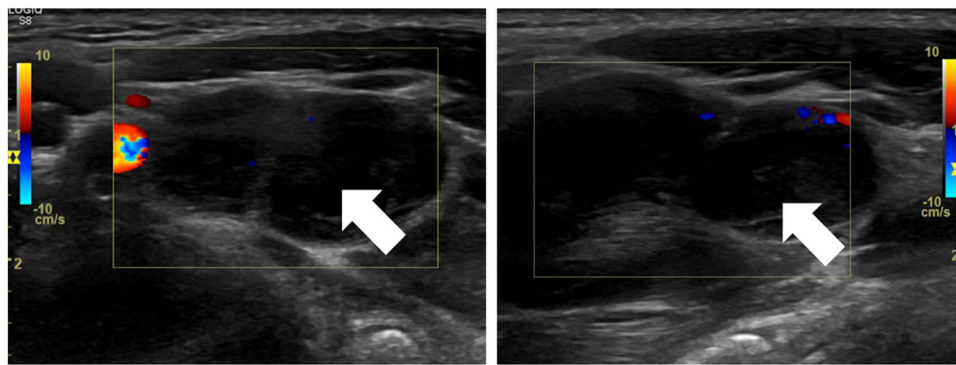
Ultrasound of the left-sided neck showed a non-specific hypoechoic mass. Left: Transverse view. Right: Sagittal view. The arrows point to the non-specific neck mass.
